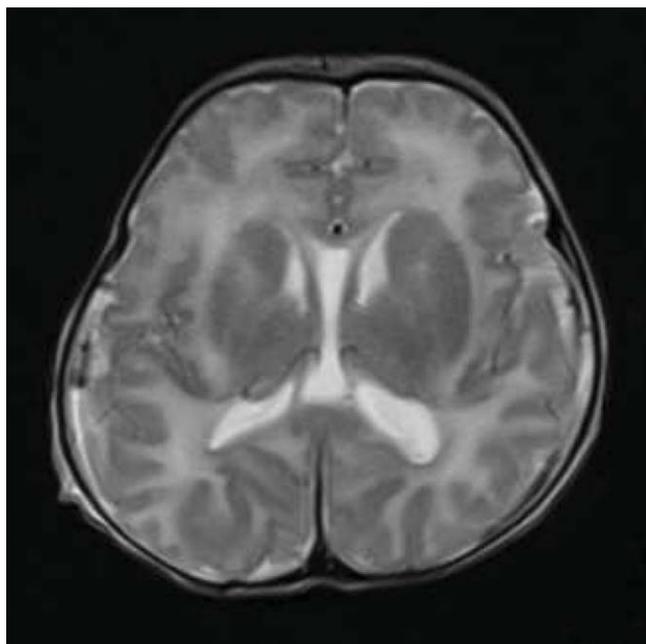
MRI brain of Patient 3 showing Polymicrogyria in the frontal lobes, septum pallidumcavum and mild hypoplasia of the inferior vermis.
